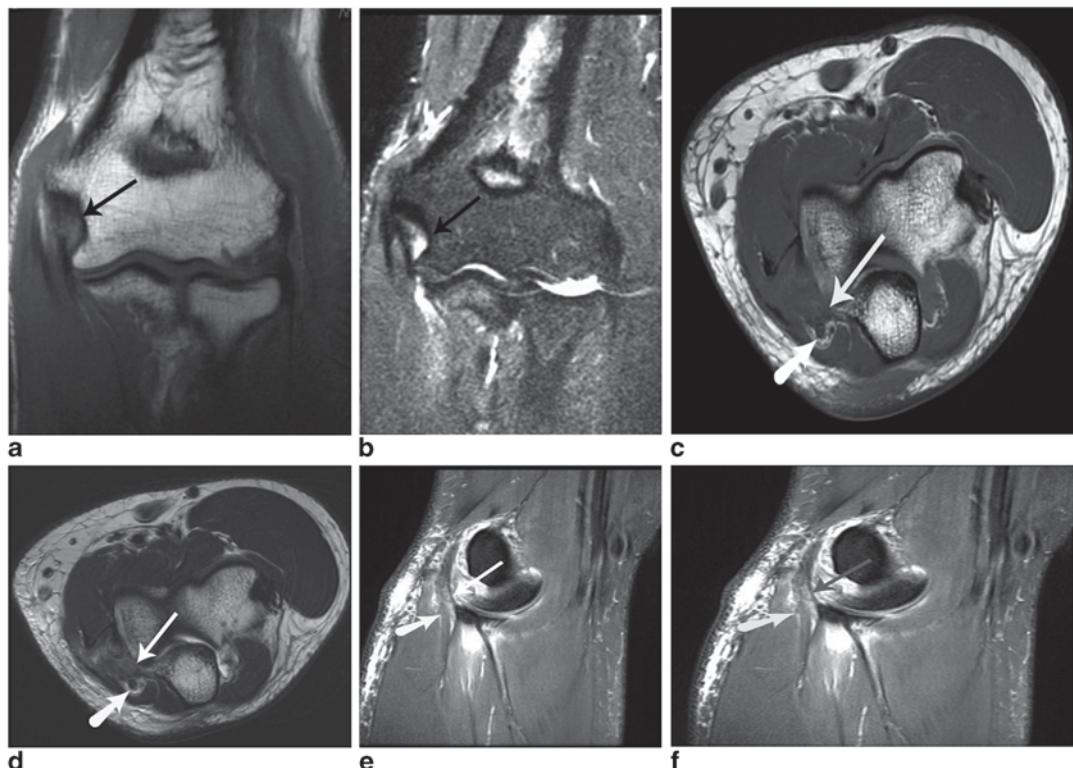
Coronal T1-weighted (a) and coronal STIR (b) images demonstrate diffuse abnormal signal intensity adjacent to the anterior band of the UCL (*arrows*) with fluid extravasation at the sublime tubercle related to a full thickness tear of the anterior band. Axial T1-weighted (c) and axial T2-weighted (d) images demonstrating diffuse
